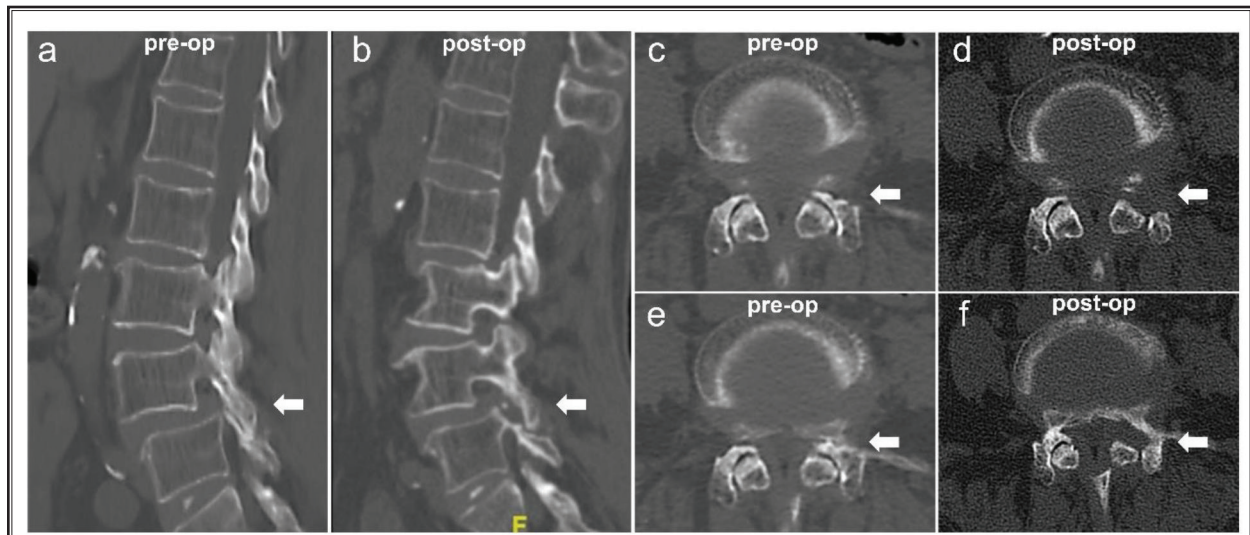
Percutaneous endoscopic lumbar discectomy performed on a 72-year-old woman diagnosed with degenerative lumbar spondylolisthesis. A, preoperative sagittal computed tomography. B, postoperative sagittal computed tomography. C and E, preoperative axial computed tomography. D and F, postoperative axial computed tomography.
